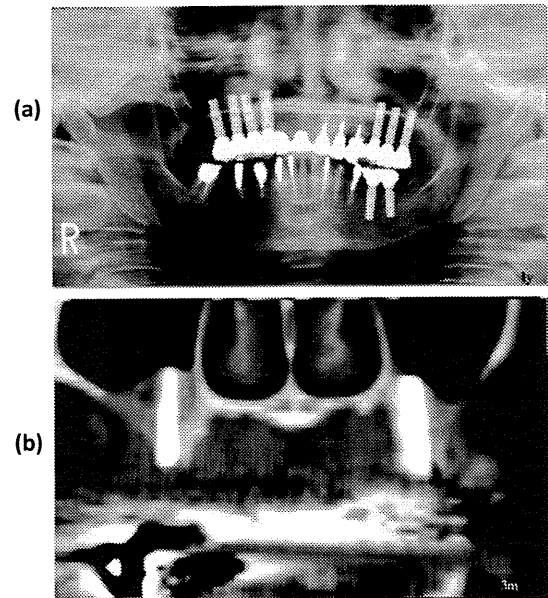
Radiographic evaluation: a)Panorama X-ray 1 year after the surgery. Mineralized tissue was observed around the dental implants. b)The CT images showed that T.E.B. had already mineralized three months after the surgery.
